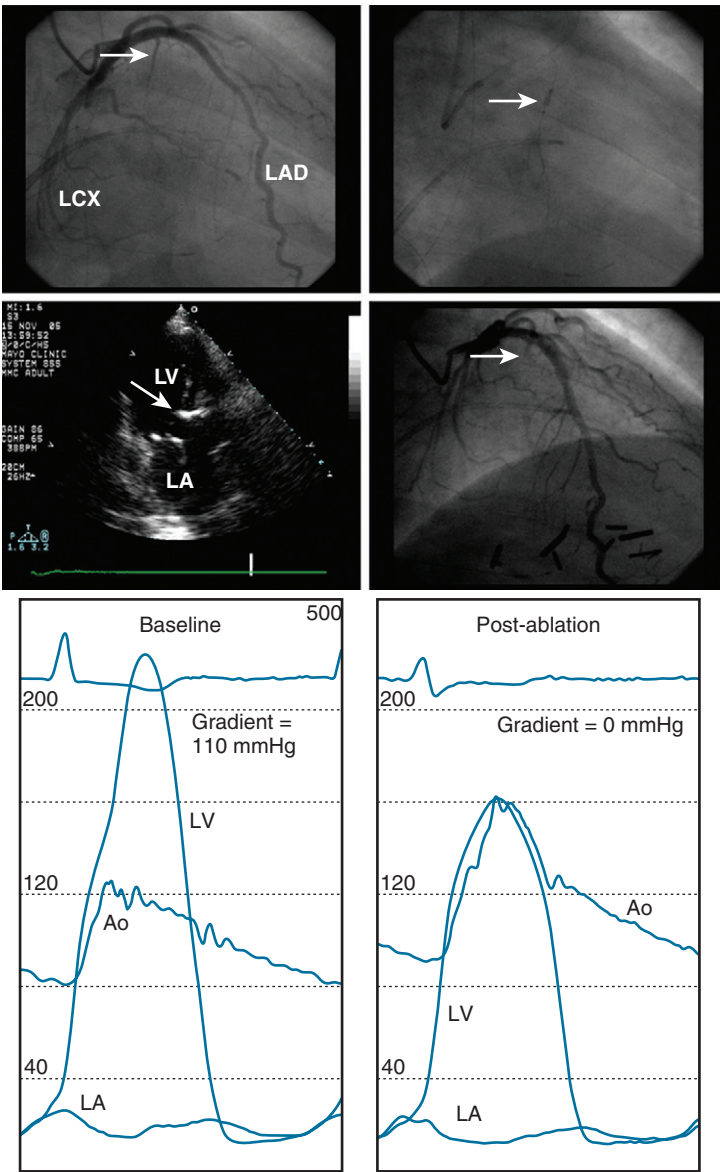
Percutaneous septal alcohol ablation. *Top left*, Baseline angiogram of the left coronary artery showing the septal perforator artery (arrow) to be used for ablation. *Top right*, An over-the-wire balloon (arrow) is inflated in the perforator artery followed by contrast injection through the balloon. *Middle left*, Echocardiographic contrast is injected through the balloon and visualized with simultaneous echocardiography. *Middle right*, Following injection of alcohol, the septal artery (arrow) is obliterated. *Bottom left*, Before septal ablation, the left ventricular outflow tract gradient is 110mmHg. *Bottom right*, Following septal ablation, there is no left ventricular outflow tract gradient. Ao, ascending aorta; LA, left atrium; LAD, left anterior descending; LCX, left circumflex; LV, left ventricle. (Reprinted from Sorajja P, Nishimura RA. Myocardial and pericardial disease. In *CathSap version 3*, by permission from American College of Cardiology Foundation.)
